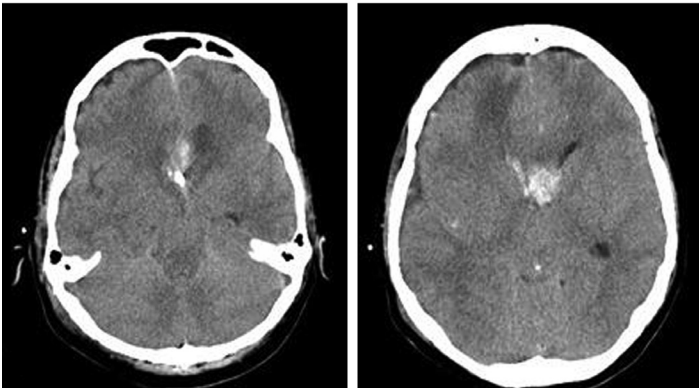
Non-contrast Head CT showing global cerebral edema, SAH, IVH, and EVD
